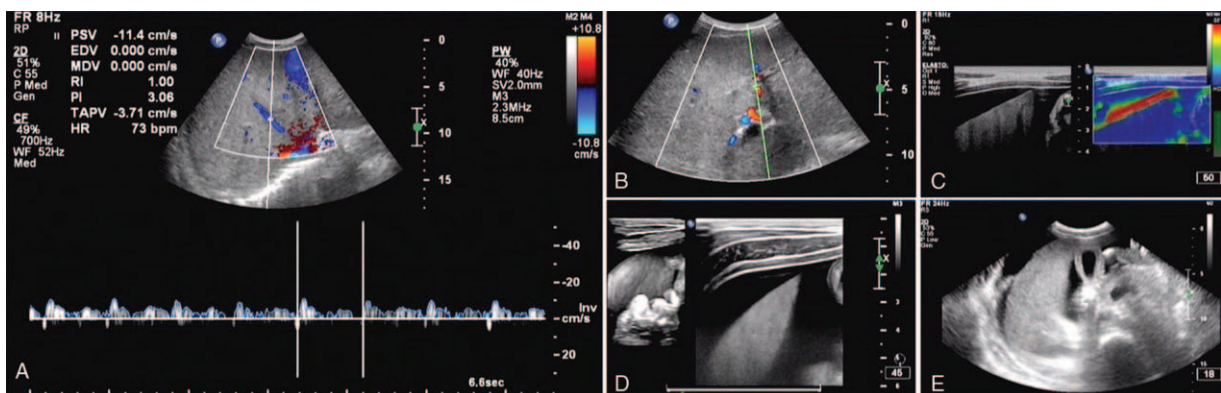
The ultrasonography of liver (A), star-shaped color (B), ascites (C, D), and gallbladder wall edema (E) can be seen in the liver ultrasonography.
